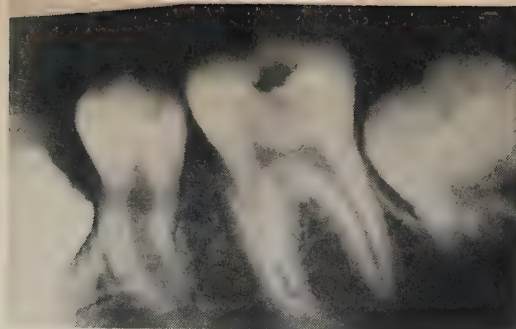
Radiograph showing almost imperceptible evidence of a third root in a lower first permanent molar.
